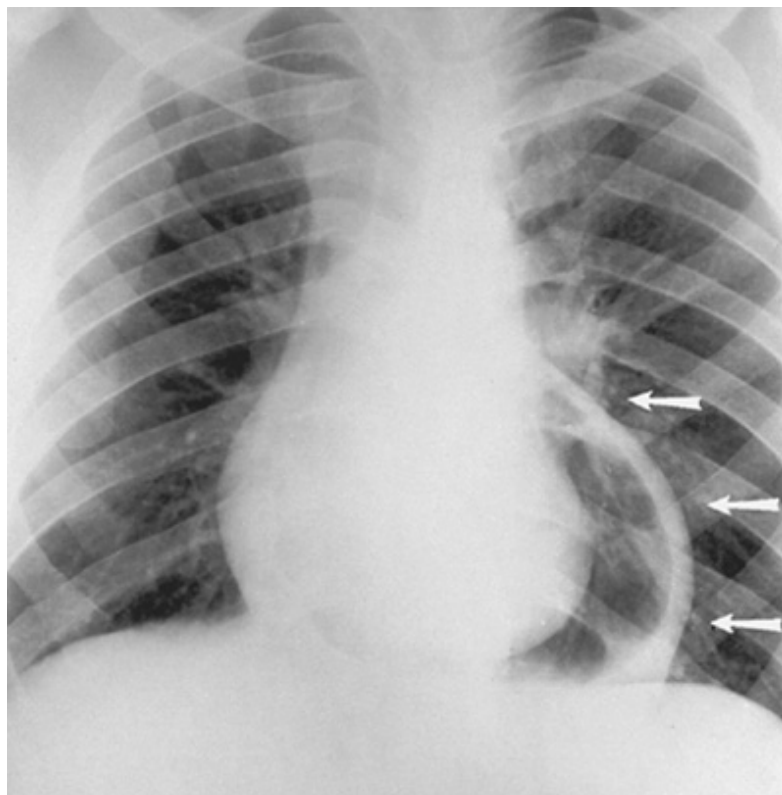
Traumatic constrictive-effusive pericarditis in a young man. Following emergent pericardiocentesis and injection of air, a radiograph was taken in the supine position. Air is confined to the left side of the pericardium. Note markedly thickened parietal layer (*arrows*).
